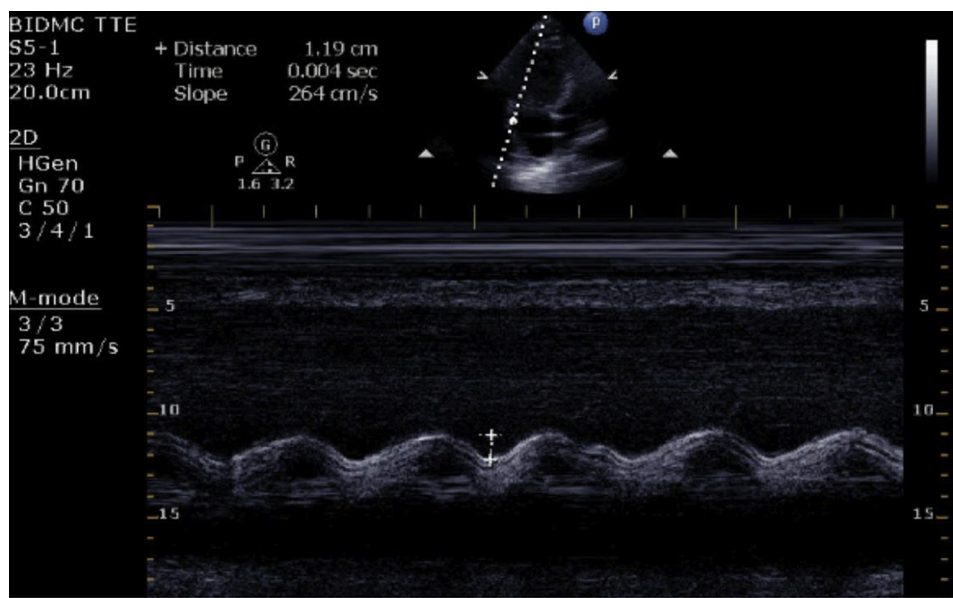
Apical four-chamber view with M mode across the tricuspid annulus. The tricuspid annular plane systolic excursion is recorded and is 1.19 cm.
